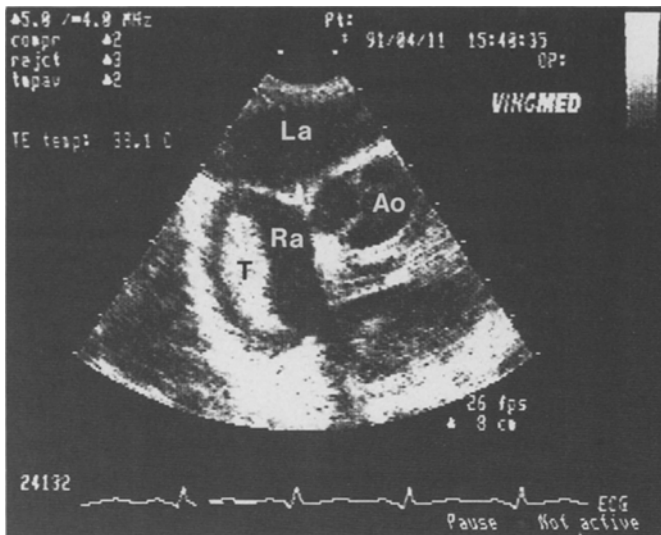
Two-dimensional transesophageal echocardiography showing a voluminous right atrial thrombus. LA, left atrium; RA, right atrium; Ao, Aorta; T, thrombus
